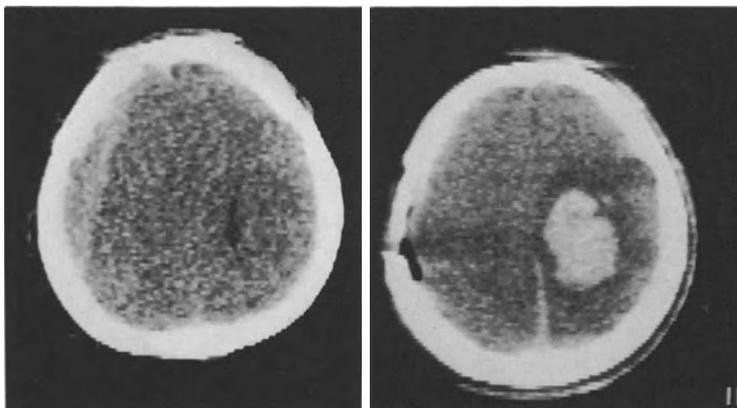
a CT 2 h after a traffic accident in a 44-year-old man with an acute subdural hematoma on the left side. b CT 24 h later, after removal of the hematoma. Large intracerebral hemorrhage in the right hemisphere. After removal of this hematoma, the condition did not improve, and the patient died 14 days later
